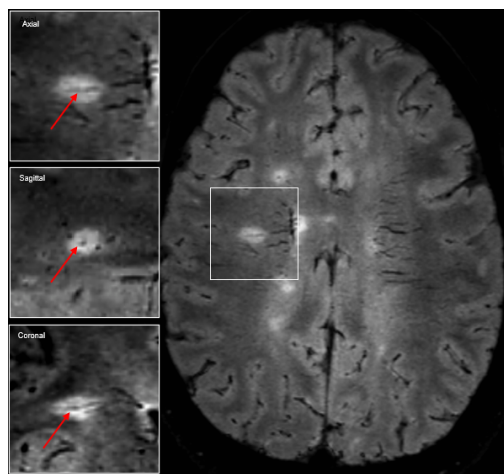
Representative MRI images of the CVS in MS. Axial 3-tesla FLAIR* showing CVS (arrowheads). Insets show magnified views. Adapted from [2].
